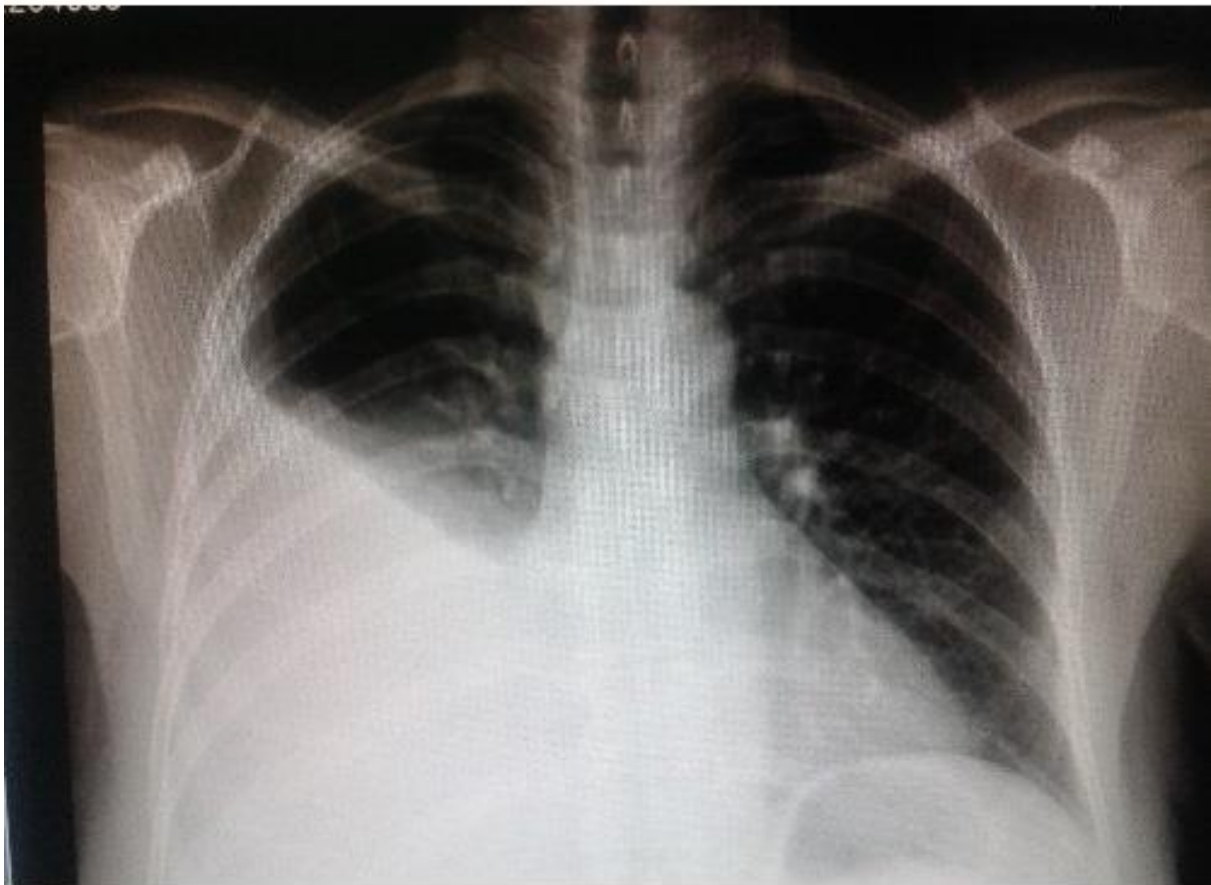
Imaging pleural effusion in chest X-ray
